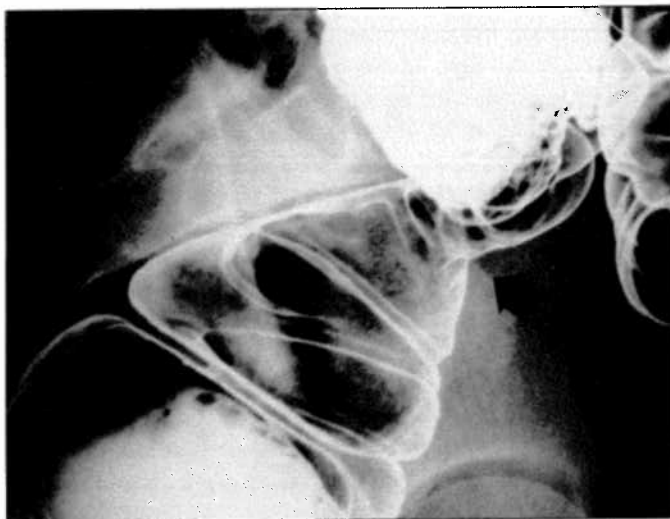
Lateral radiograph of the rectosigmoid region demonstrates a smoothly tapered area of narrowing (arrow).
